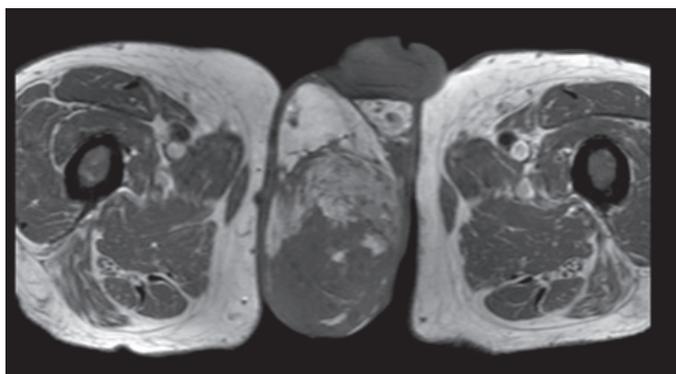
T1 magnetic resonance imaging scan axial view showing enlarged right testicle occupying most of the scrotal space.
